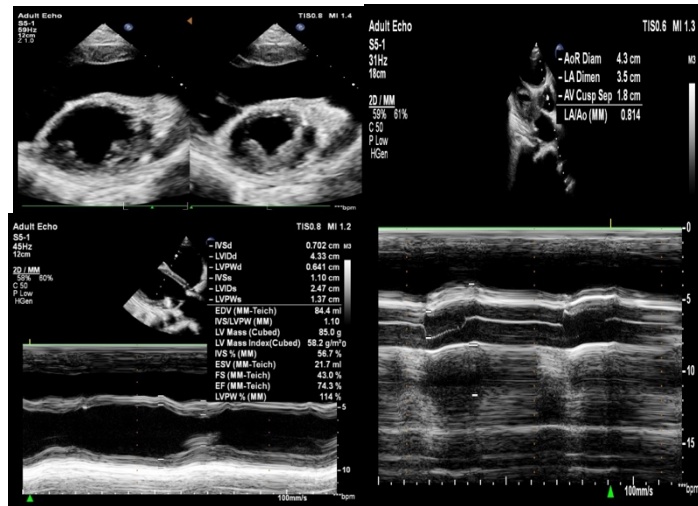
Echocardiography RSMH December 7, 2023
